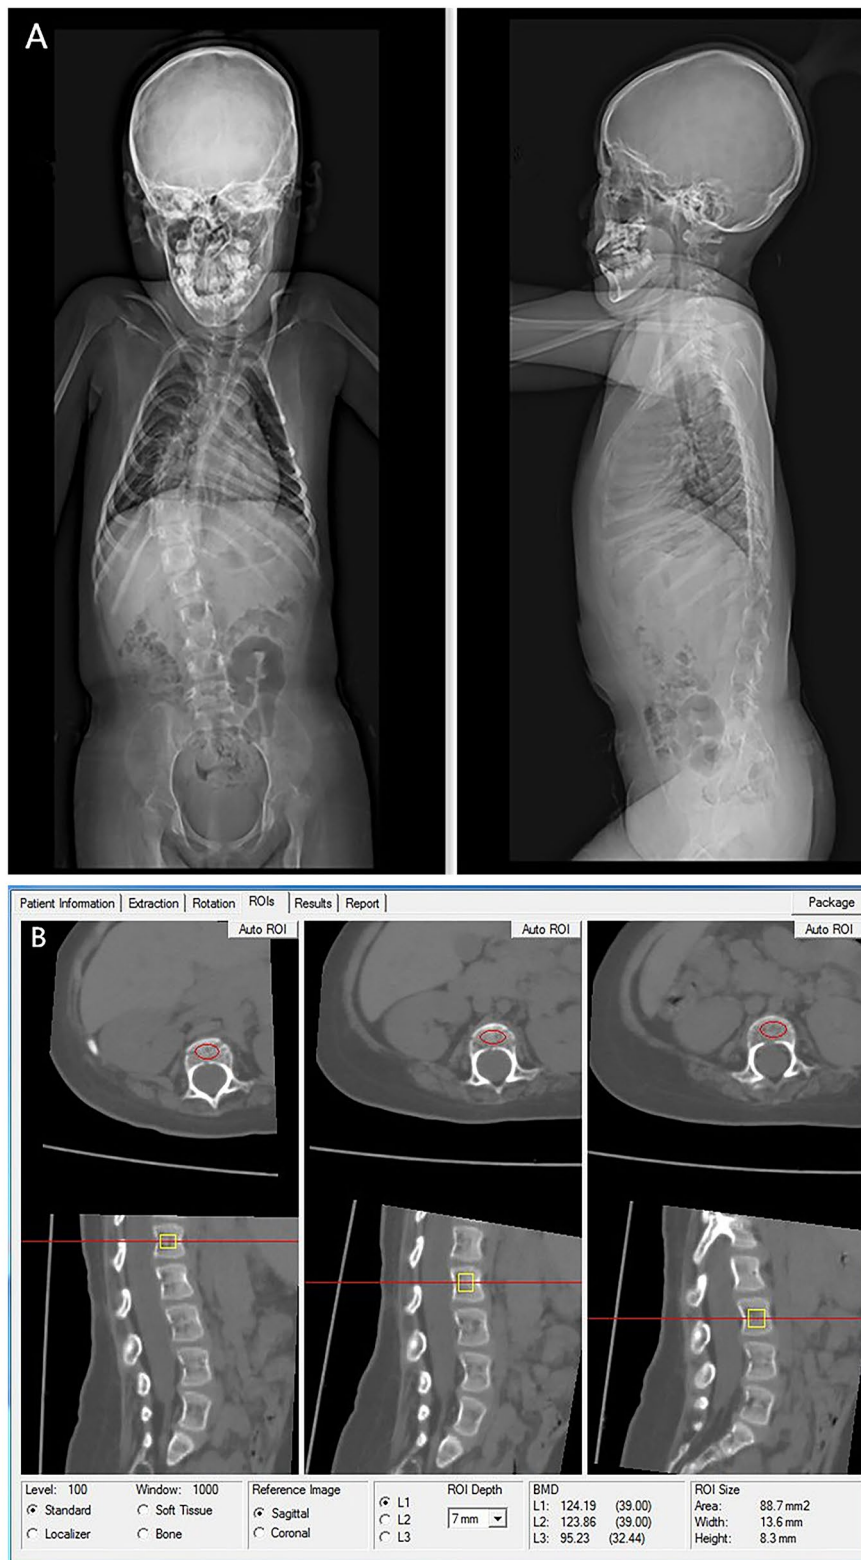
A 7-year-old girl with SMA type 2. (A) Routine plain radiography of the spine shows a thoracolumbar scoliosis. (B) The measurements of L1, L2, and L3 vertebral trabecular volumetric bone mineral density (BMD) are shown. The BMD of L1, L2, and L3 are 124.19 mg/cm³, 123.86 mg/cm³, and 95.23 mg/cm³, respectively; the average lumbar volumetric BMD is 109.31 mg/cm³, and the Z score is -2.02
